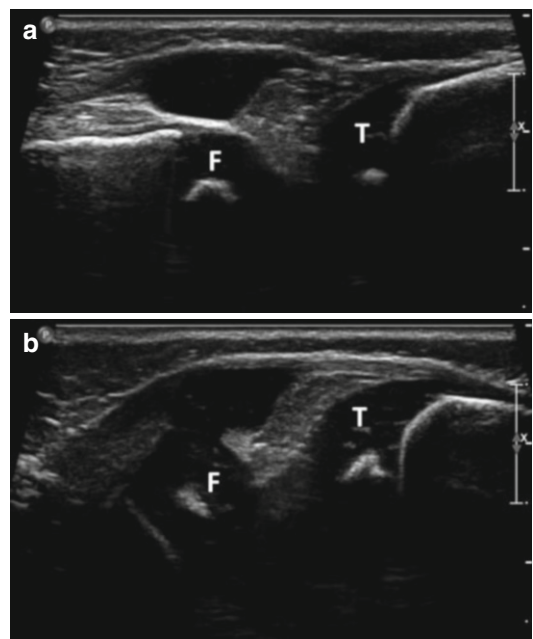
Hyperextension deformity of the knee in a child with high lumbar level myelomeningocele; an ultrasound scan in extension demonstrates the hyperextension deformity but without any dislocation or proximal displacement of the proximal tibial epiphysis on the distal femoral epiphysis (a). An ultrasound scan in flexion (b) demonstrates that the deformity is easily correctible. *F* distal femoral epiphysis, *T* proximal tibial epiphysis
